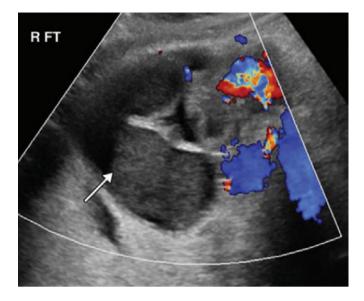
Color Doppler ultrasound shows a dilated tube containing debris and liquid fluid (arrow). Note the absence of thickening of the tube wall or hyperemia.⁹
